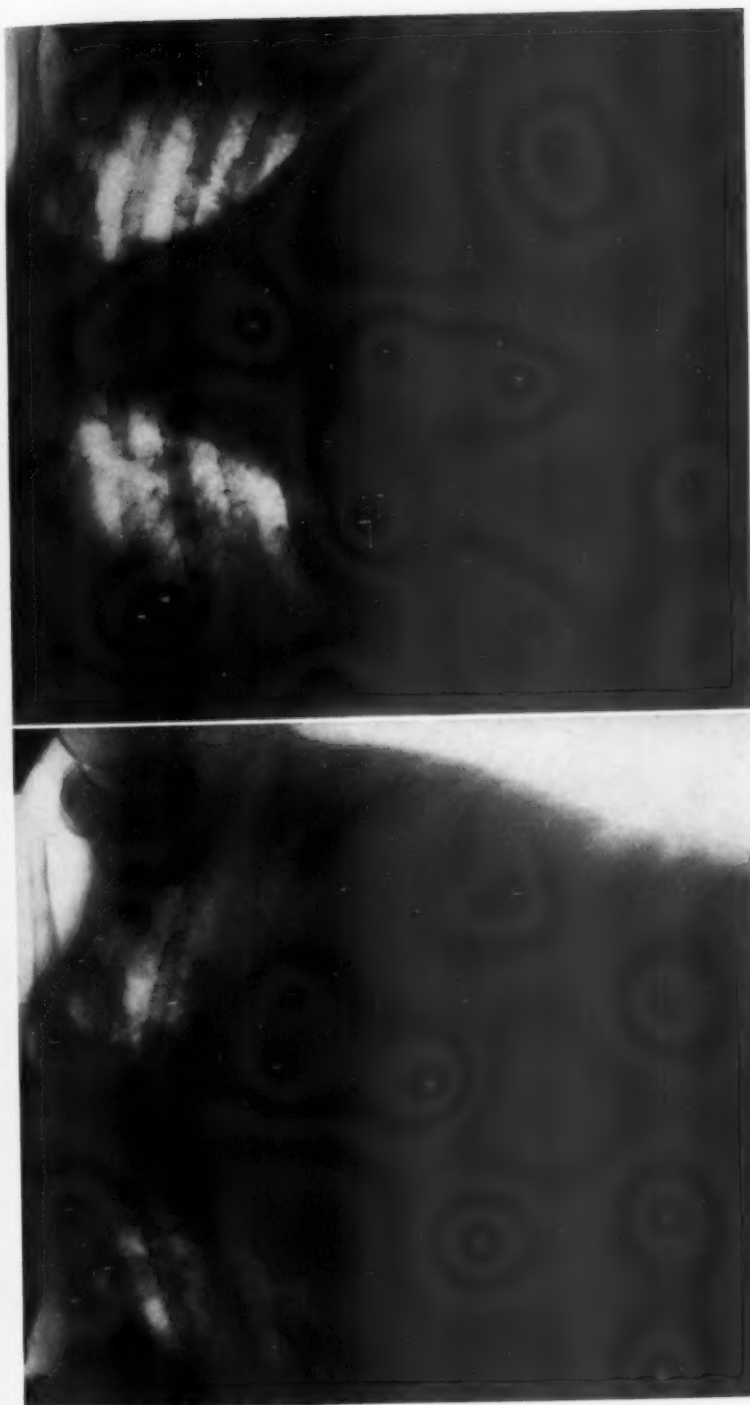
Roentgen-ray film of patient H. K. taken with a portable machine two days before operation. The portable machine was used so there could be a comparison with the pictures taken after operation.
